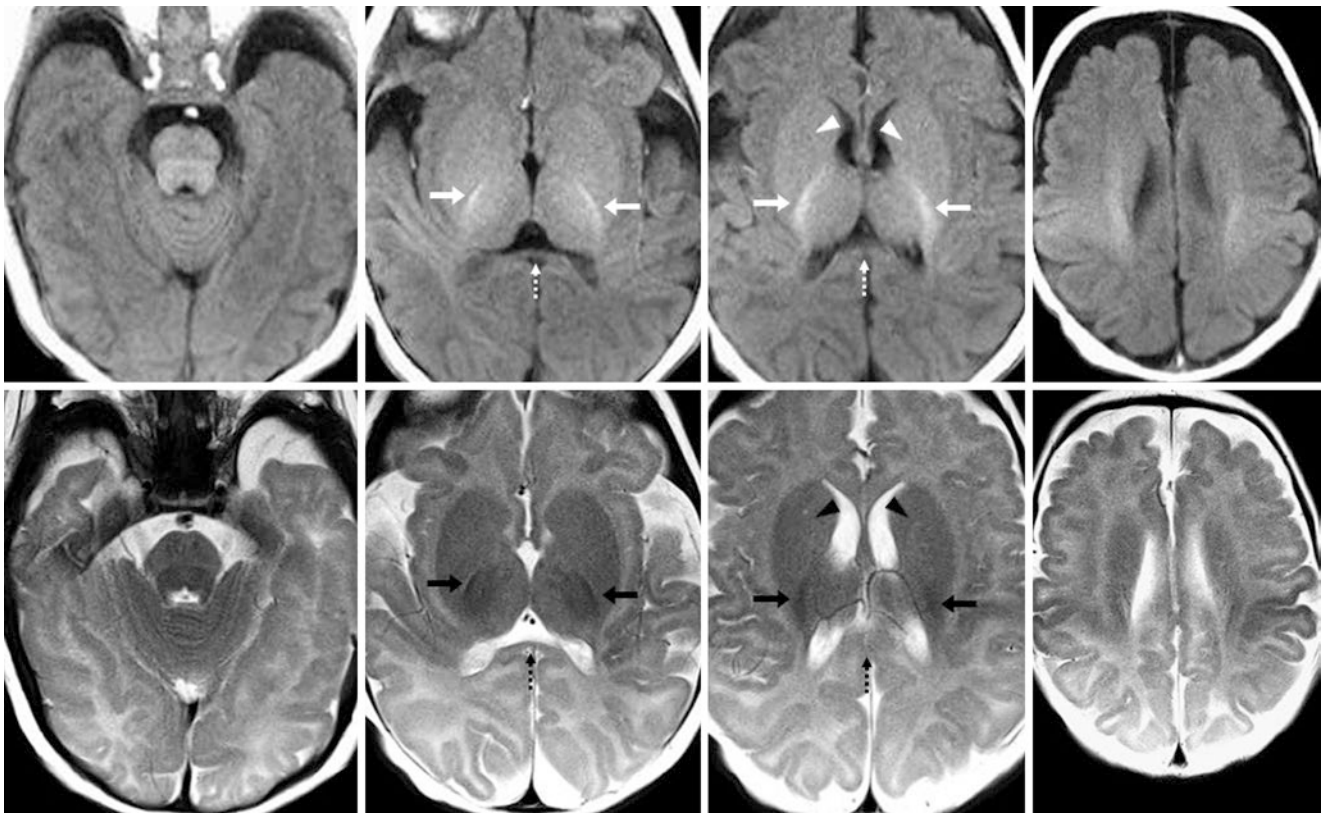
Comparison case of mild hypomyelination in cobalamin C defect. A 14-week-old with developmental delay had a 3T MRI with GE T1WIs (*top row*) and SE T2WIs (*bottom row*). Although there appears to be maturation (*i.e.*, myelination) of the PLICs-corticospinal
